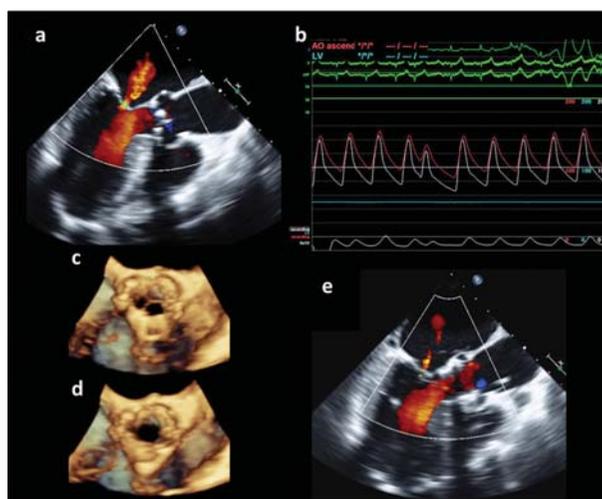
Successful management of the severe hypotension and deployment of the transcatheter stent-prosthetic aortic valve; transesophageal echocardiogram after wire removal revealed (a) mild mitral regurgitation; (b) invasive pressure monitoring showed recovery of blood pressure; 3D transesophageal echocardiogram revealed normal valve function in diastole (c) and systole (d); 2D transesophageal echocardiogram revealed only mild mitral regurgitation after the balloon-expandable transcatheter stent-prosthetic aortic valve implantation (e)
